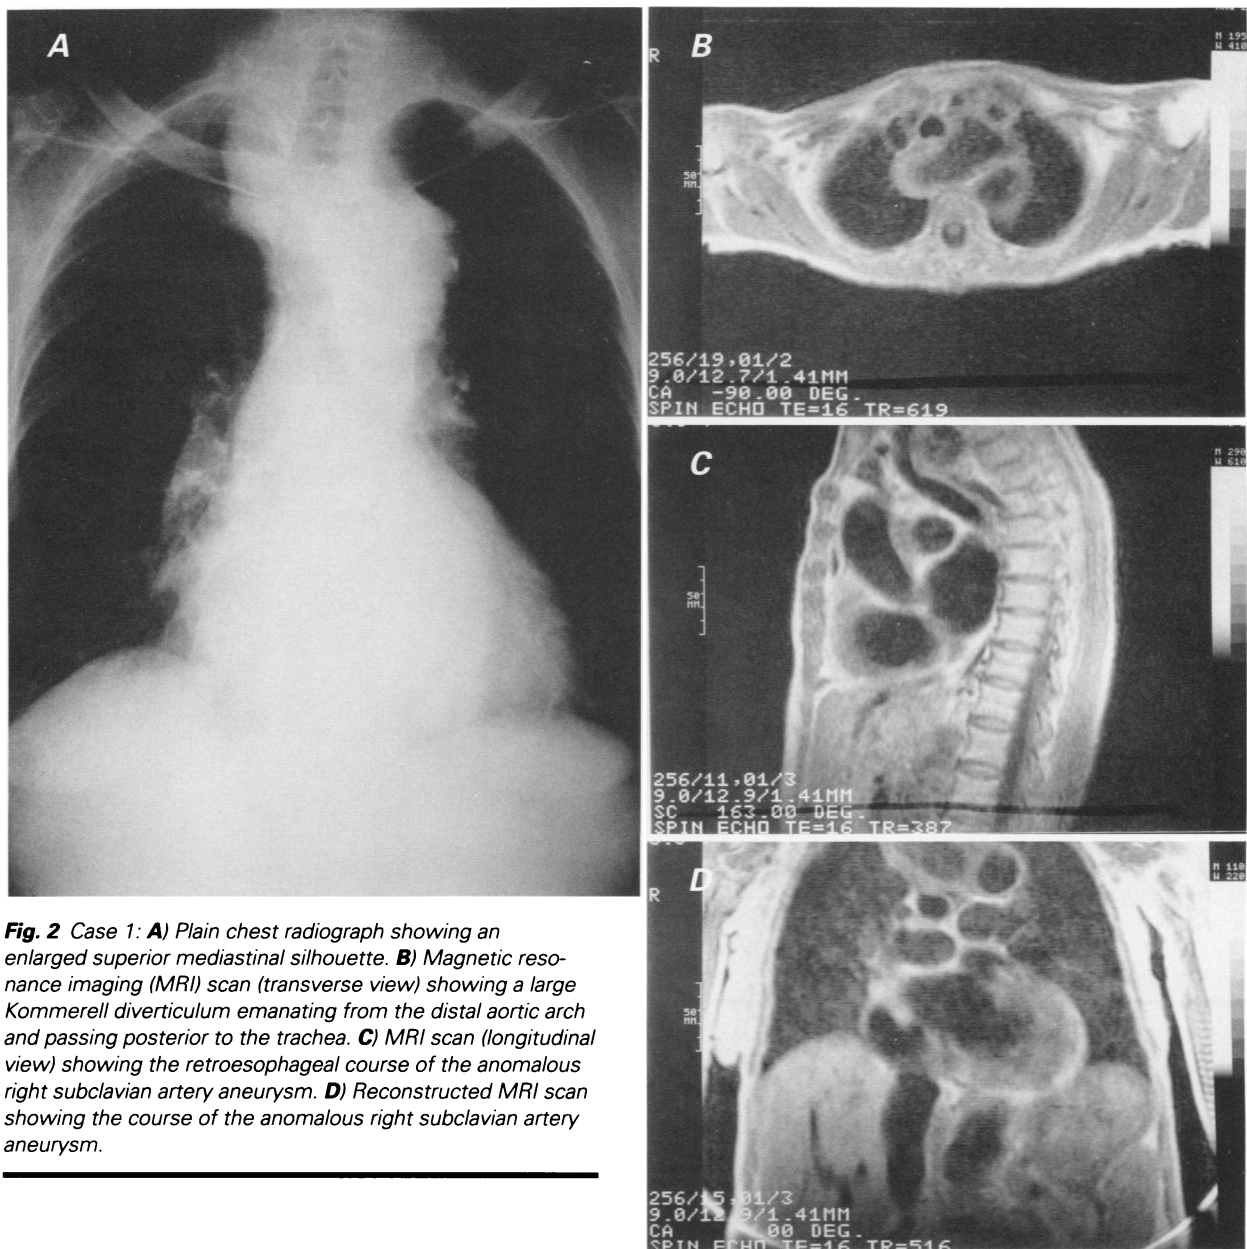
Case 1: A) Plain chest radiograph showing an enlarged superior mediastinal silhouette. B) Magnetic resonance imaging (MRI) scan (transverse view) showing a large Kommerell diverticulum emanating from the distal aortic arch and passing posterior to the trachea. C) MRI scan (longitudinal view) showing the retroesophageal course of the anomalous right subclavian artery aneurysm. D) Reconstructed MRI scan showing the course of the anomalous right subclavian artery aneurysm.
